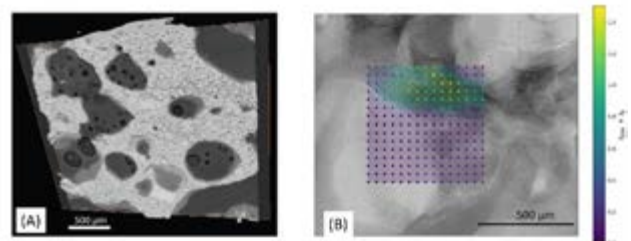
A) 3D CT image of trabecular bone B) WAXD-scanning map overlaid on 2D X-ray radiograph, showing variation in ultrastructural peak intensity, reflecting 3D orientational changes in mineralized fibril [5]. Scale bar is 500 μm in both A) and B).
